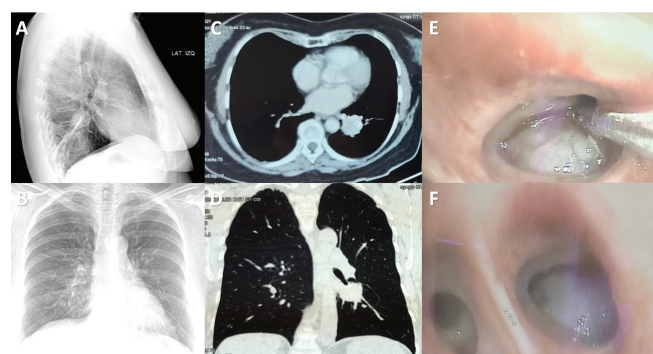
Preoperative imaging studies. Posteroanterior and lateral view chest radiograph showing a calcified nodular lesion in the left hilar region associated with reticular lesions and bronchiectasis (A,B), calcified nodular lesion involving the endobronchial region of the left lower lobe (C,D), a flexible bronchoscopic study identifying a friable, pearly white, endobronchial lesion in the left lower lobe (E,F).
